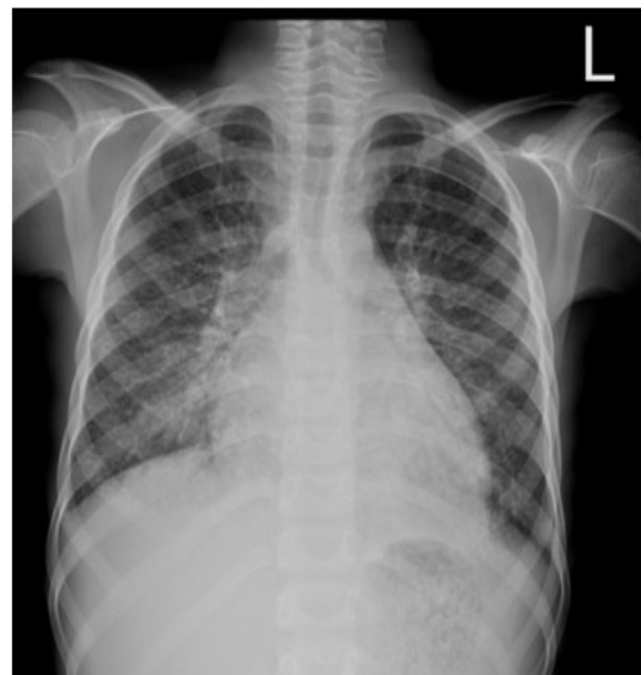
Chest x-ray of the 12yrs old girl with diotheria myocarditis showing bilateral upper lung vascular diversion and reticulon which suppestive of grade II pulmonry edema .
